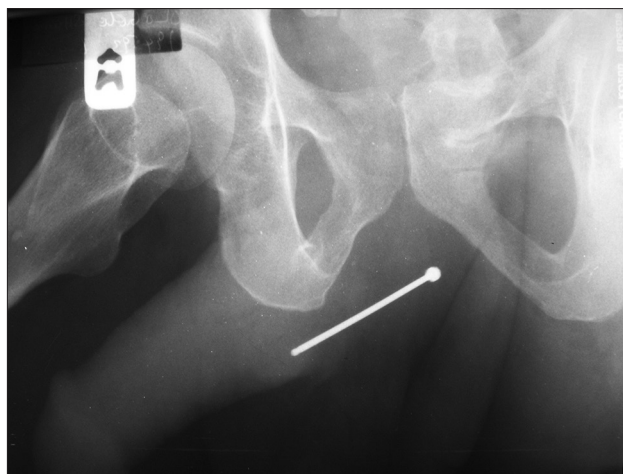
Oblique pelvic X-ray showing foreign body in the region of penile and bulbar urethra
